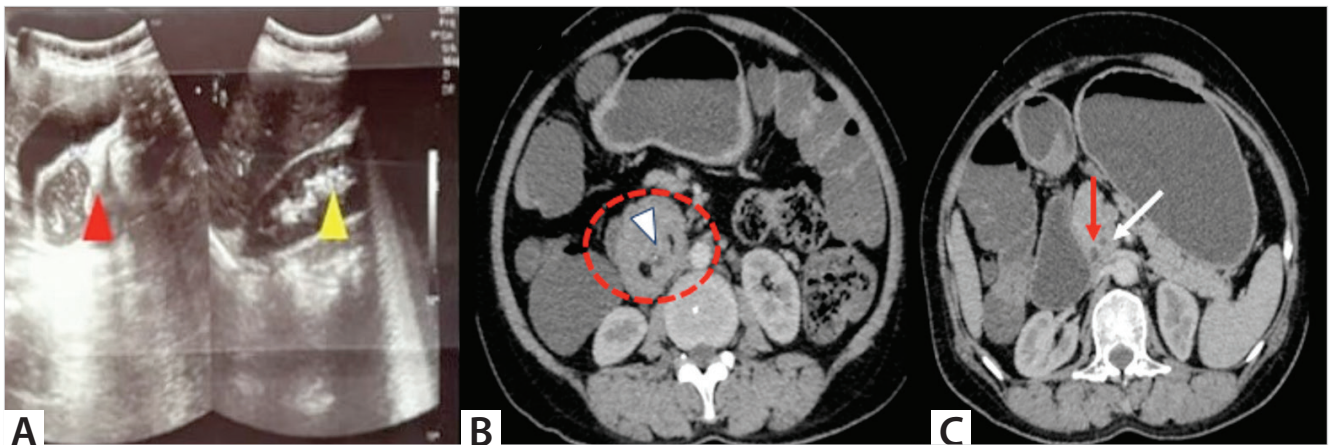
Case 2: A. Ultrasonography of the abdomen showing the polypoidal mass as lead point (red arrow head) and target sign (yellow arrow head) suggesting intussusception of bowel. B. Axial section of the CT scan suggests duodenoduodenal intussusception (dotted circle) and the lead point (white arrow head). C. Further sections on CT scan suggest dilated CBD (red arrow) and pancreatic duct (white arrow).
